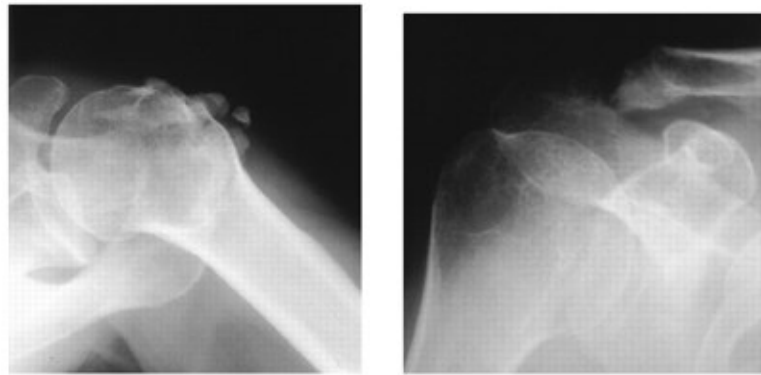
Postoperative radiographs showing heterotopic ossification. Left: Axillary radiograph demonstrating heterotopic bone in the vicinity of an anterior acromioplasty. Right: Zanca (acromioclavicular joint) radiograph demonstrating heterotopic bone formation in the space created by resection of the lateral portion of the clavicle. ⁽⁵¹⁾
